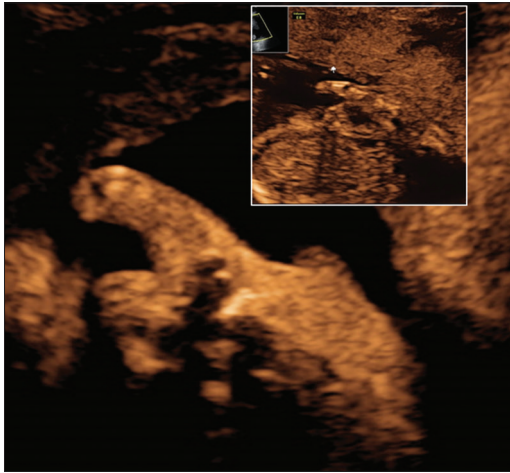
Ultrasound images showing camptodactyly (fixed pointing of index finger) in two fetuses with Stuve–Wiedemann syndrome
